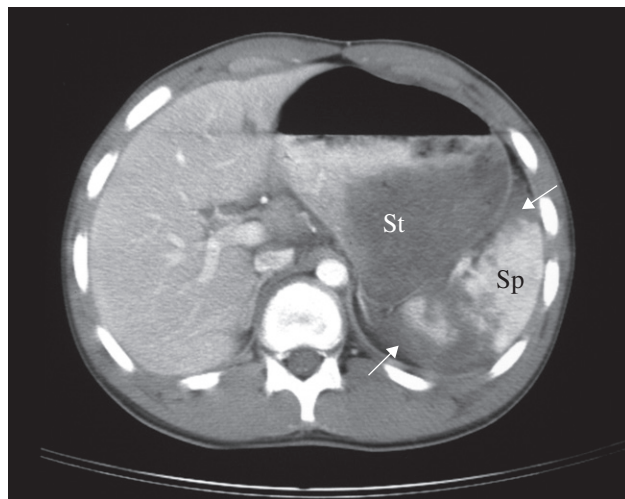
Ruptured spleen on CT. The spleen is shattered with low density blood (arrows) adjacent to the fragments. Sp, spleen; St, stomach.
